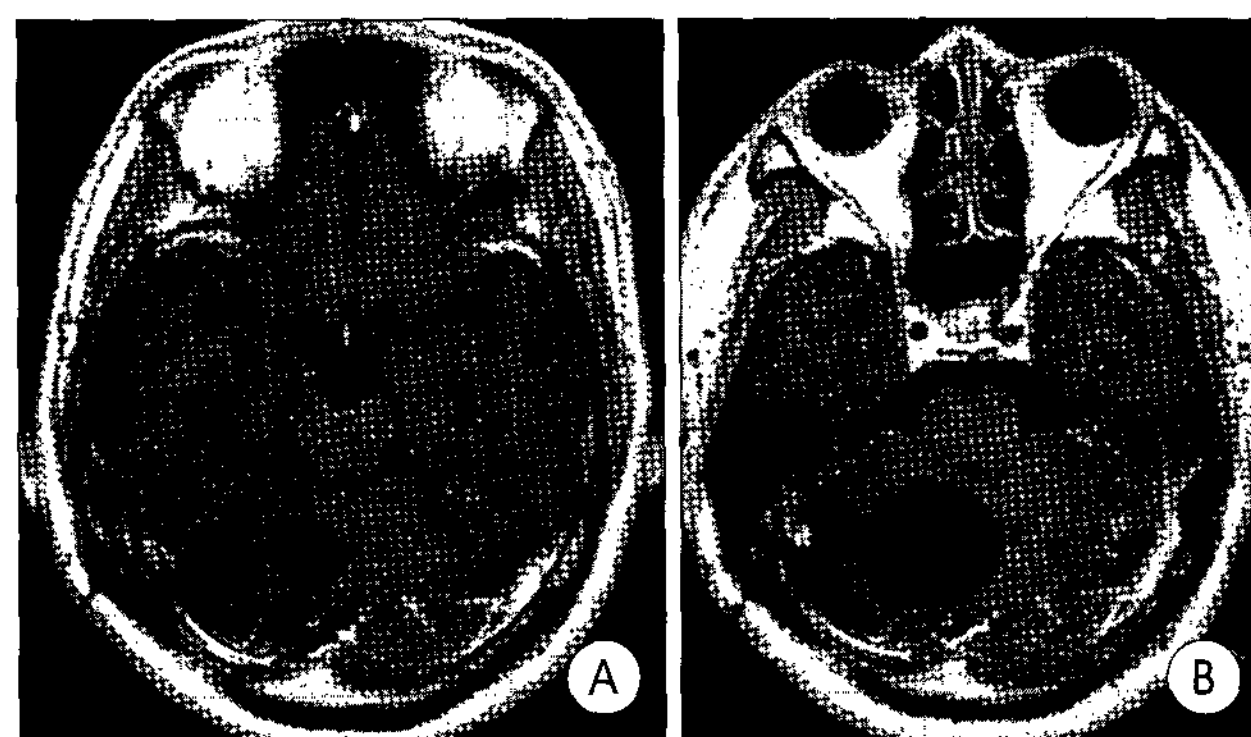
Case 7 : Axial gadolinium enhanced T1 weighted magnetic resonance(MR) images. Pre-radiosurgical MR images(A) showing a small cystic tumor in the right cerebellar hemisphere. Post-radiosurgical MR images(B) 29months after the radiosurgery showing the enlargement of tumor.
